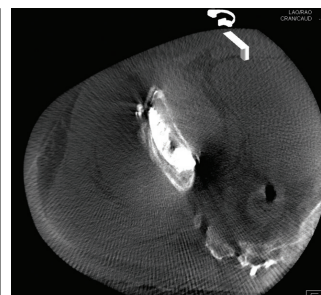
Postprocedural cone-beam CT scan showing cement distribution in the right superior acetabulum.
